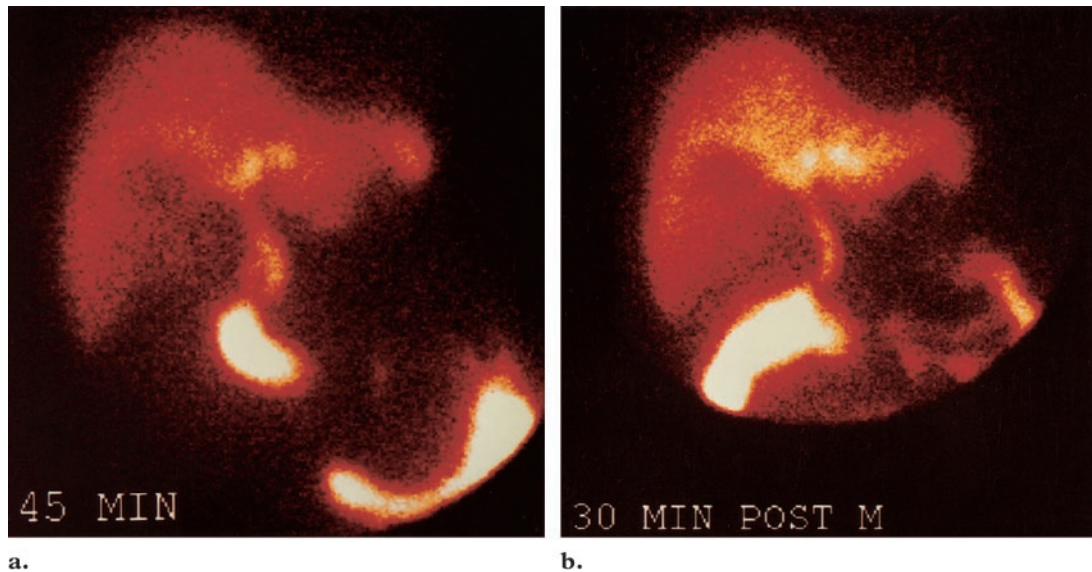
Utility of morphine in the diagnosis of acute cholecystitis with Tc-99m HIDA cholescintigraphy. On images obtained 45 minutes after radiotracer administration (a) and 30 minutes after intravenous administration of morphine (b), the gallbladder is not visualized. Nonvisualization of the gallbladder after administration of morphine is diagnostic of acute cholecystitis in the appropriate clinical setting.
